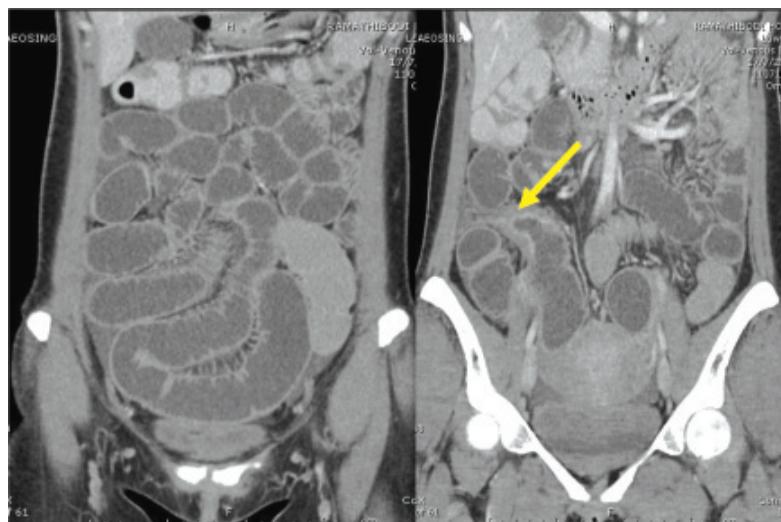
Tuberculosis as a cause of SBO; coronal views of CT abdomen show SBO and the site of obstruction is at distal ileum (arrow). The cause of obstruction is proved to be tuberculosis.
